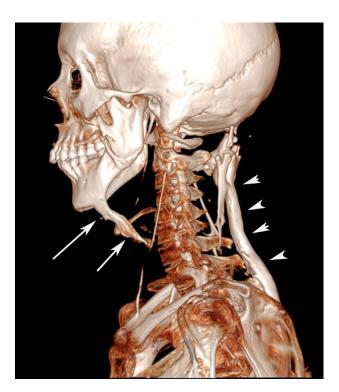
Three-dimensional CT image of the cervical spine shows heterotopic bone formations descending from the occiput (arrowheads) and jaw (arrows), corresponding to ossification confluent with muscles and ligaments.
